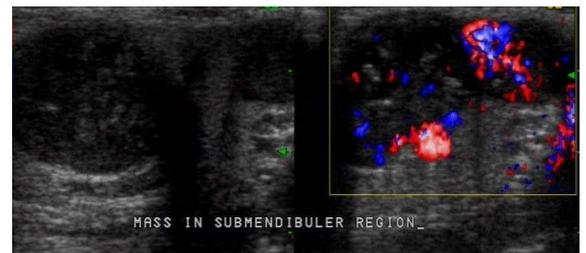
Lymphoma: Ultrasound image showing rounded homogeneously hypoechoic lymph nodes with diffuse (central and peripheral) vascularity.
